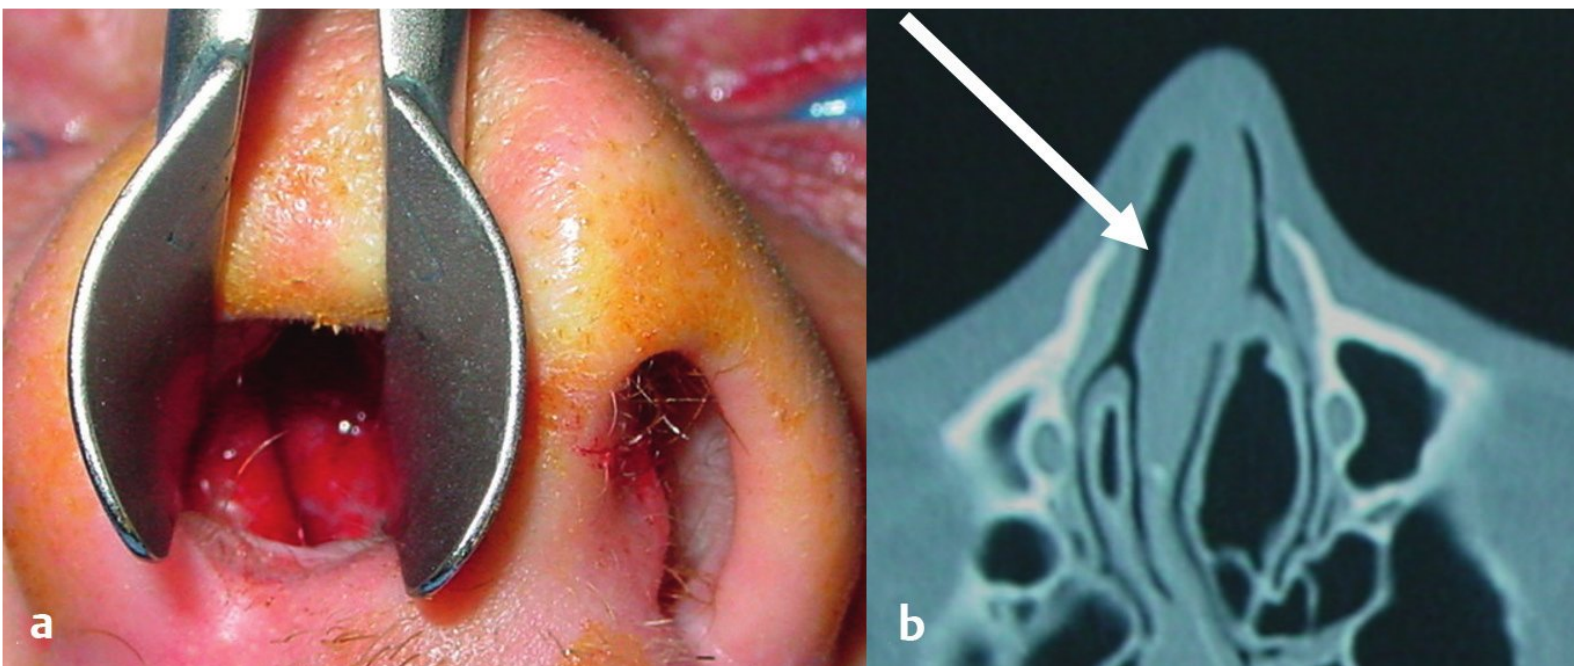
(a) Nasal septal hematoma that requires immediate drainage. (b) CT scan confirms diagnosis.
